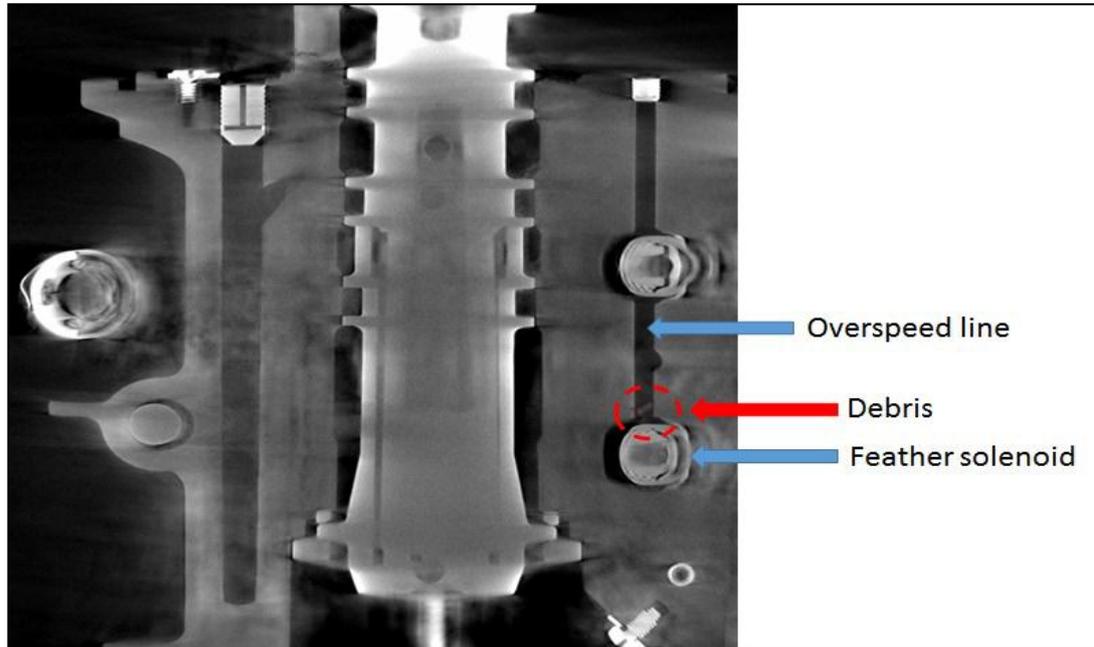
CT Scan - Debris Inside the PVM Overspeed Line
